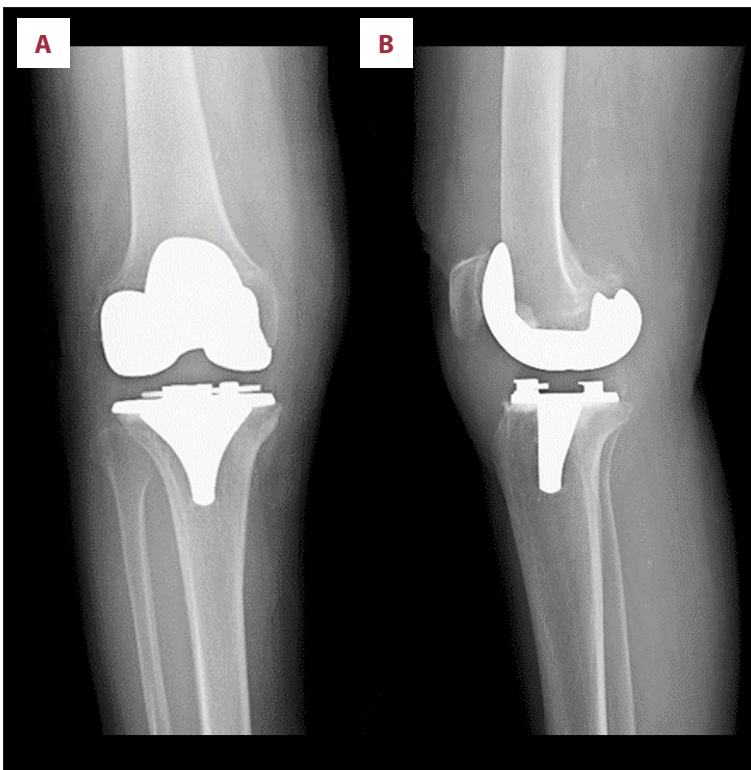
Postoperative radiograph of the right knee (Case 1), anteroposterior (A) and lateral (B) views.
